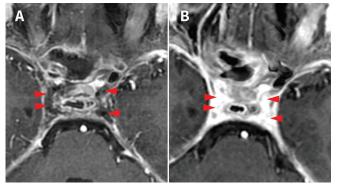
Contrast-enhanced magnetic resonance imaging scan from a 13-year-old boy on the first day of hospital admission (A) shows filling defects (arrowheads) in the cavernous sinus, indicating multiple venous thrombosis, which improved by day 24 of admission (B).
